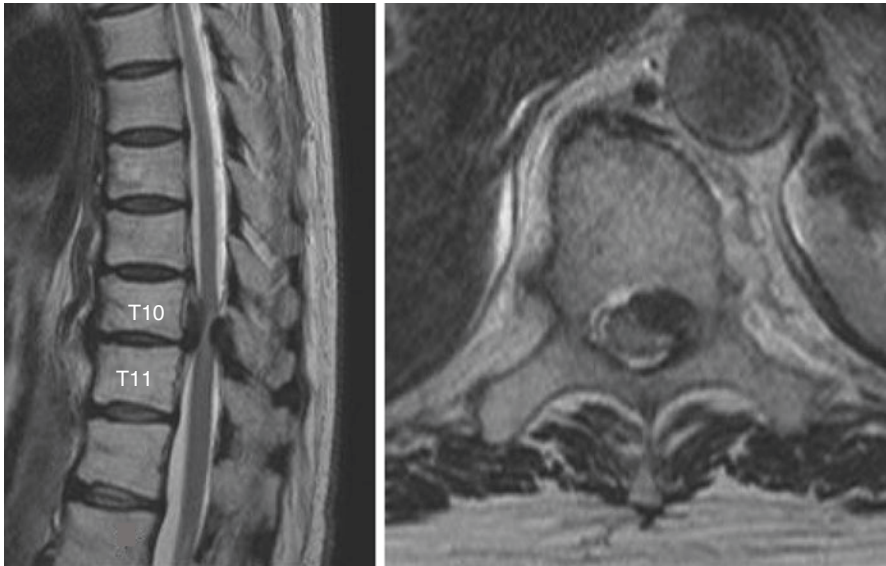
A thoracic MRI in a typical TDH case. The patient is a 77-year-old female with T10–T11 DH suffering from incomplete paraplegia (Case 1)
